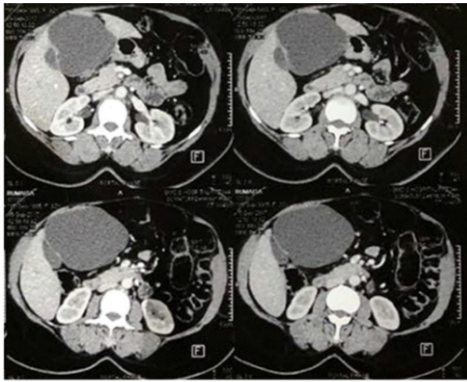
TRIPLE PHASE CT IMAGE REVEALING CYST IN SEGMENT 4 OF THE LIVER
